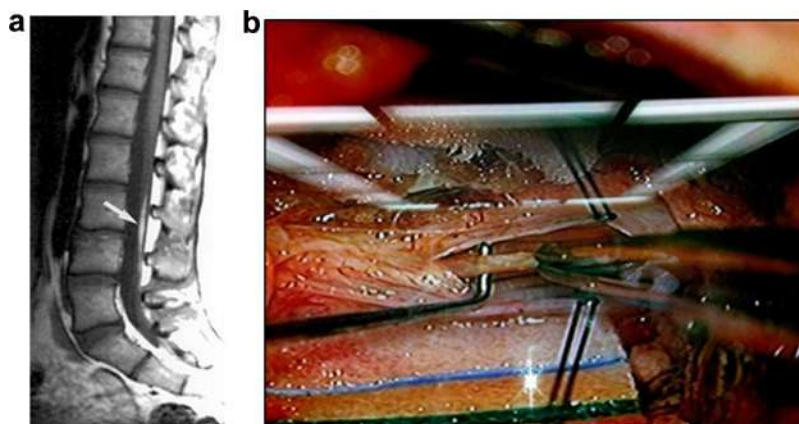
a: Tethered cord syndrome: conus at the normal level (L1), fatty filum suggestive of tethered cord syndrome (Sagittal view lumbar spine, T1 weighted MRI). b: Tethered cord syndrome: the thickened filum terminale at the L2 level, just before division. (Intraoperative photograph of the lumbar spine thecal sac and the durotomy).
